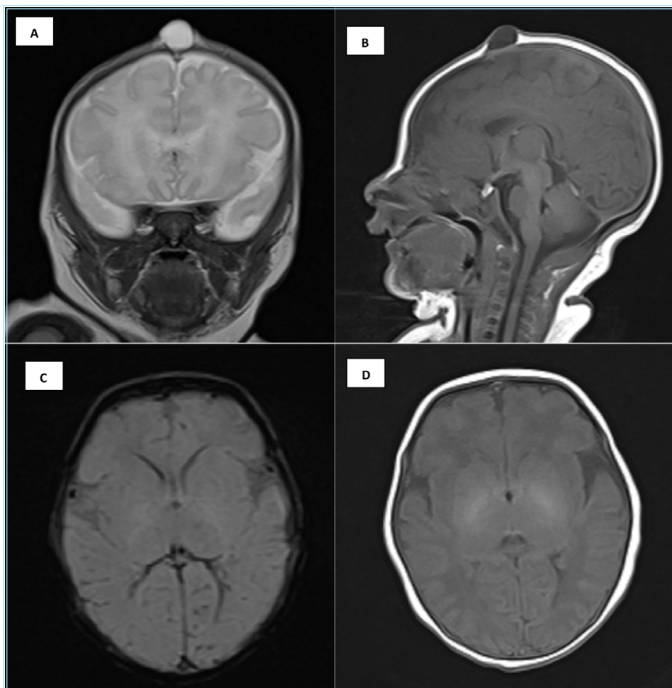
(A-D) MRI images in the same child obtained using tailored protocols showed an anterior fontanelle inclusion cyst and brain parenchyma with better resolution
